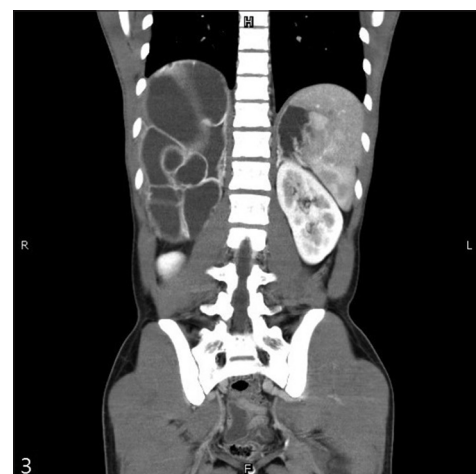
Coronal computed tomographic image showing multiple hepatic cysts with septations
